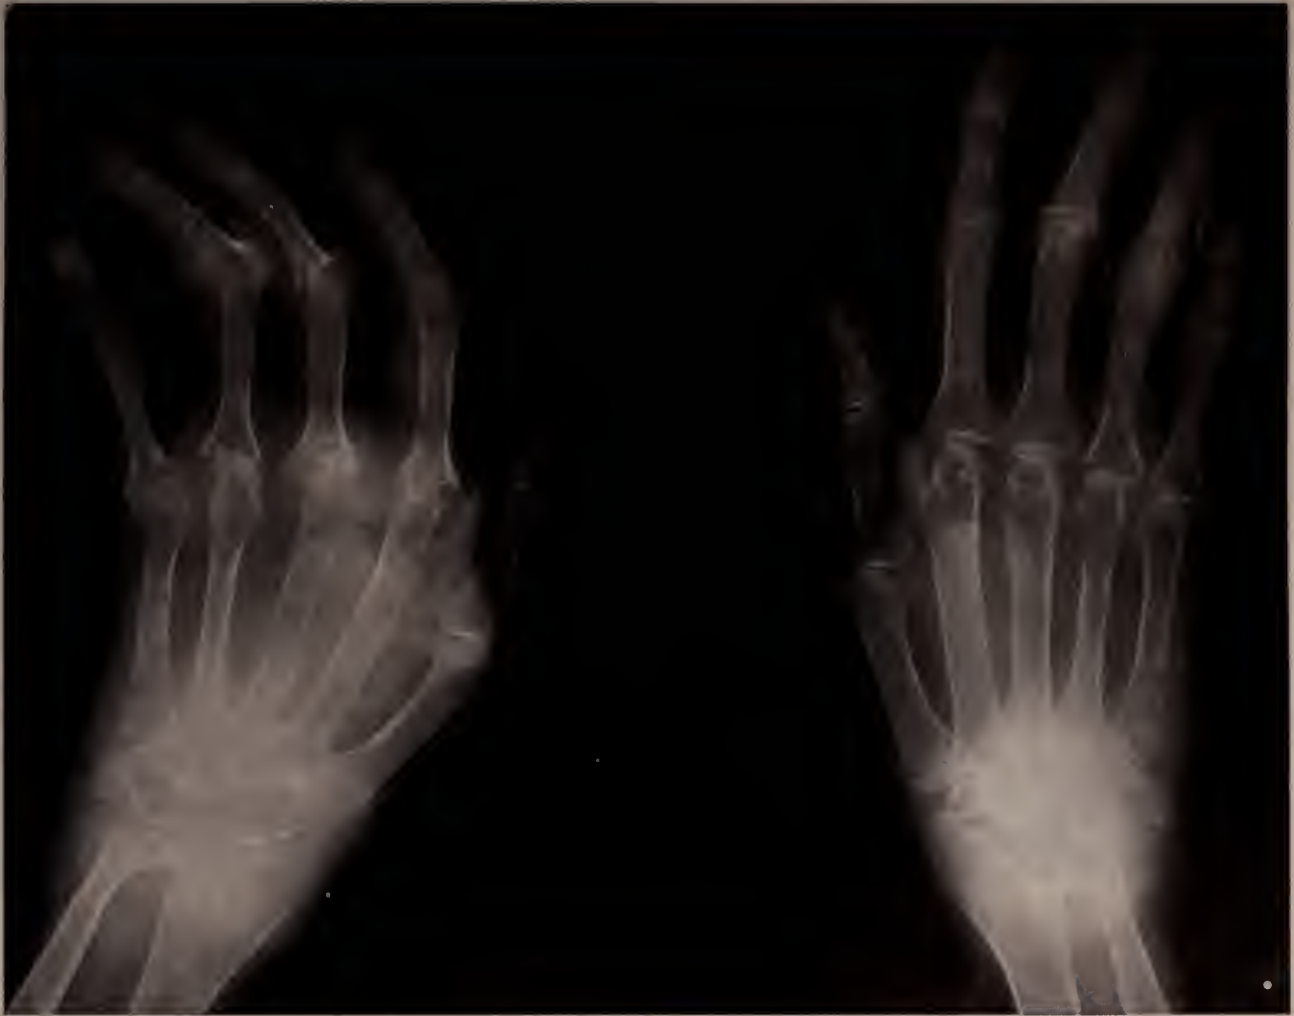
Severe erosive destruction of carpal bones, MCP's, and PIP's without radiographic evidence of tophi.
